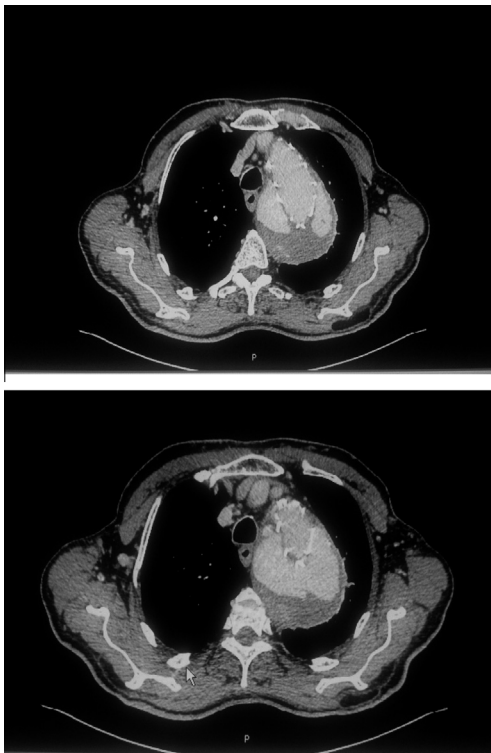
(a) and (b) Preoperative contrasted computed tomography.
